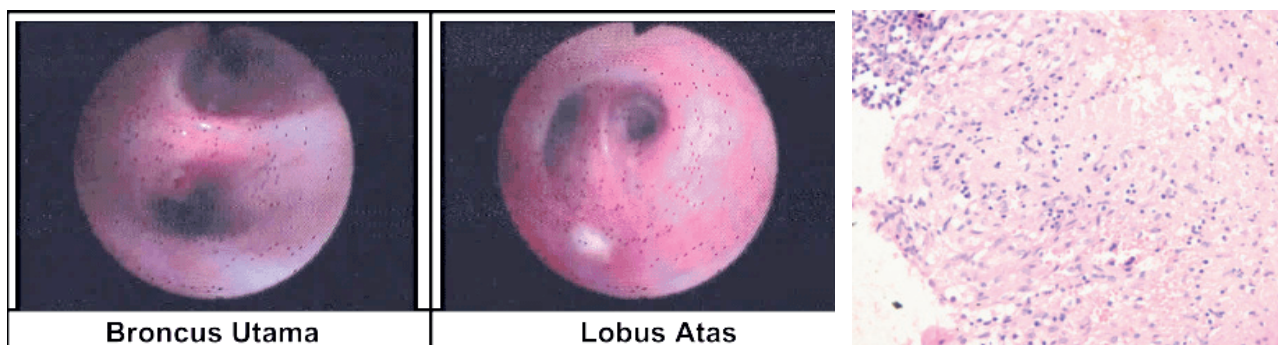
FOB of Mr. H (right) appears intralumen mass of the right superior lobe bronchus; CT-guiding FNAB results (left) show granulomatous inflammation
